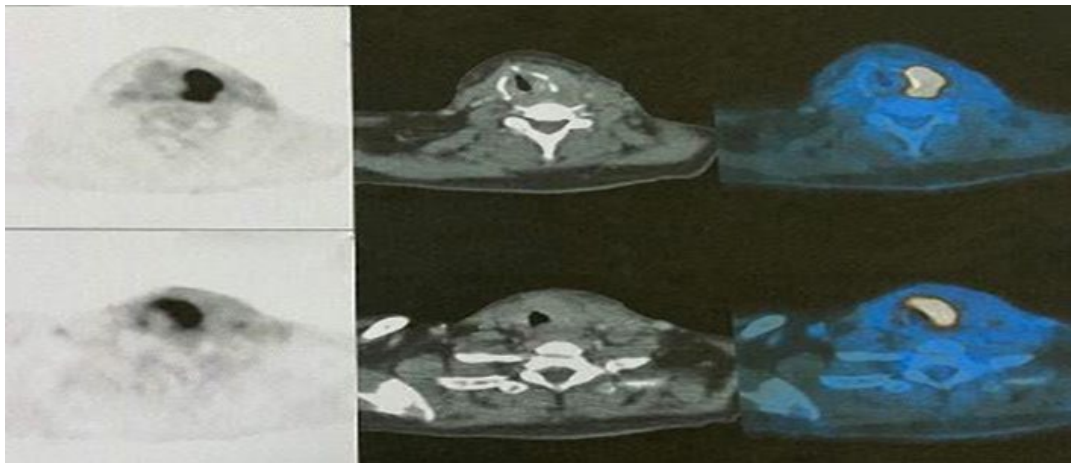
18F-FDG PET/CT scan demonstrating large enhancing mass (SUV max up to 23.8) with ill-defined margins and hypodense centers in the left thyroid bed, extending superiorly at the level of the larynx (approx. 6.1 x 3.5 x 3.5 cm).
